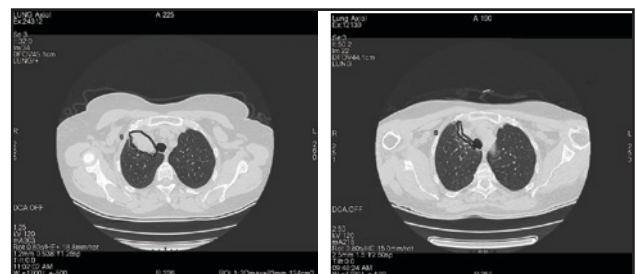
Thoracic CT scan before and after treatment
